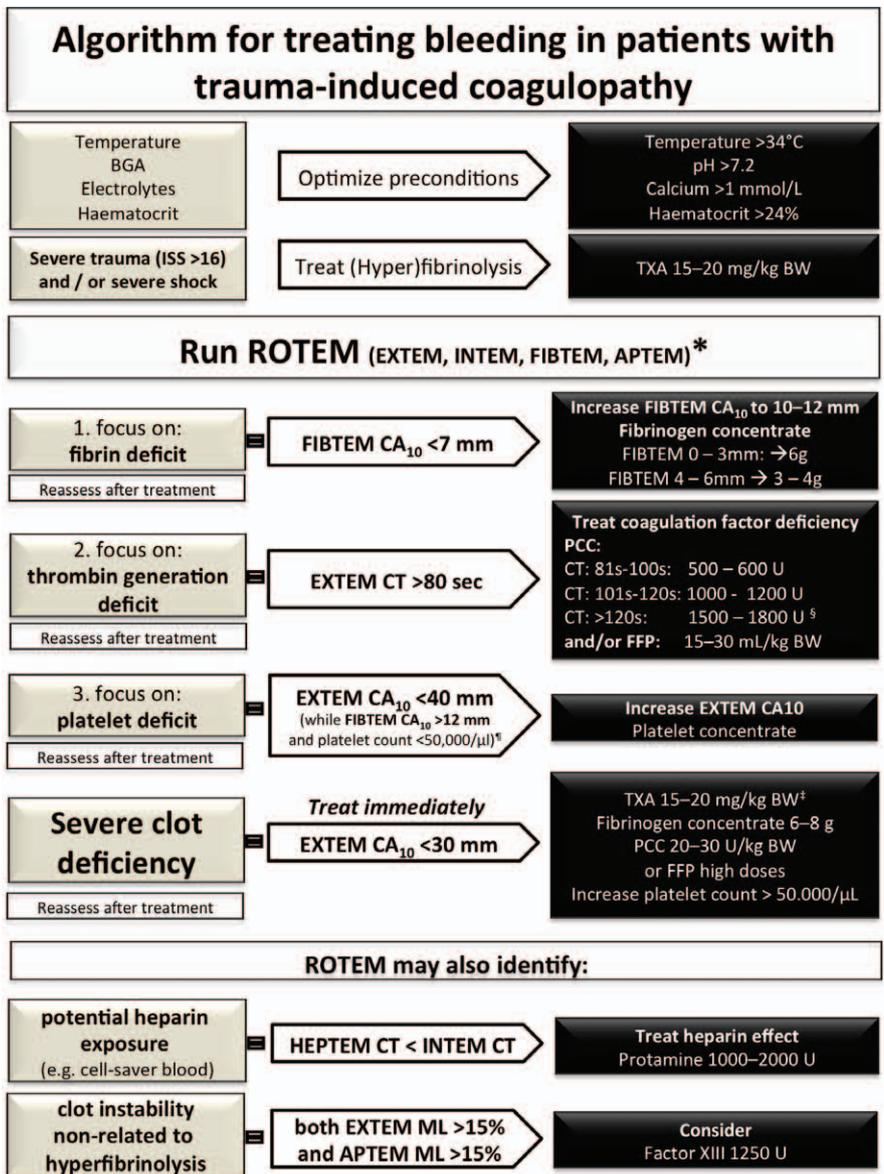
ROTEM-guided treatment algorithm: managing trauma-induced coagulopathy and diffuse microvascular bleeding (AUGA Trauma Hospital, Salzburg, Austria).¹⁸ The algorithm is the standard operating procedure for ROTEM-guided hemostatic therapy on admission of trauma patients to the emergency room. Hemostatic agents suggested for use in clinics where coagulation factor concentrates are not available. *For patients who are unconscious or known to be taking platelet inhibitor medication, Multiplate tests (adenosine diphosphate [ADP] test, arachidonic acid [ASPI] test, and thrombin receptor activating peptide-6 [TRAP] test) are also performed. [§]If decreased ATIII is suspected or known, consider coadministration of ATIII. [‡]Any major improvement in extrinsically activated test plus aprotinin (APTEM) parameters compared with corresponding EXTEM parameters may be interpreted as a sign of hyperfibrinolysis. [¶]Only for patients not receiving TXA at an earlier stage of the algorithm. Traumatic brain injury: platelet count 80,000 to 100,000/μL. Normal values: EXTEM/APTEM coagulation time (CT): 38 to 79 seconds; EXTEM/APTEM clot amplitude at 10 minutes (CA10): 43 to 65 mm; EXTEM/APTEM maximum lysis (ML) < 15%; FIBTEM CA10: 7 to 23 mm; intrinsically activated test (INTEM) CT: 100 to 240 seconds. CA10 = clot amplitude at 10 minutes; BGA = blood gas analysis; BW = body weight; Ca = calcium; CT = clotting time; FFP = fresh frozen plasma; ISS = injury severity score; MAPTECF = maximum clot firmness; ML = maximum lysis; PCC = prothrombin complex concentrate; TXA = tranexamic acid.
